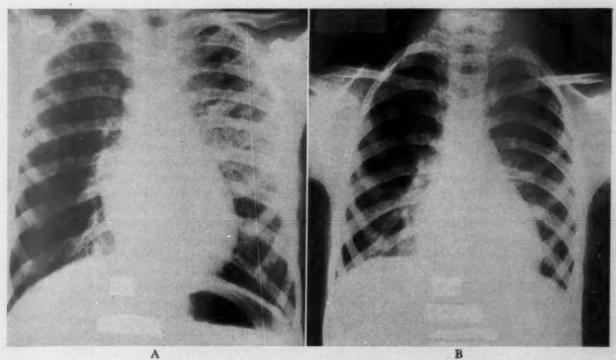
Case 27. X-ray films of the chest. A, taken at sea level soon after arrival. Abnormalities are observed mostly in the left lung. B, two days later both lung fields appear normal. The only treatment was bed rest and oxygen for six hours the night of admission.
